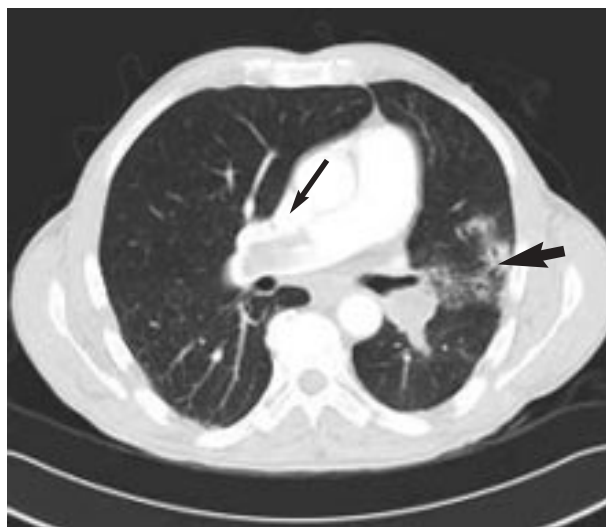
CT chest examination showing large pulmonary arterial mass (thin arrow), mediastinal lymphadenopathy and left upper lobe infiltrate (thick arrow).
